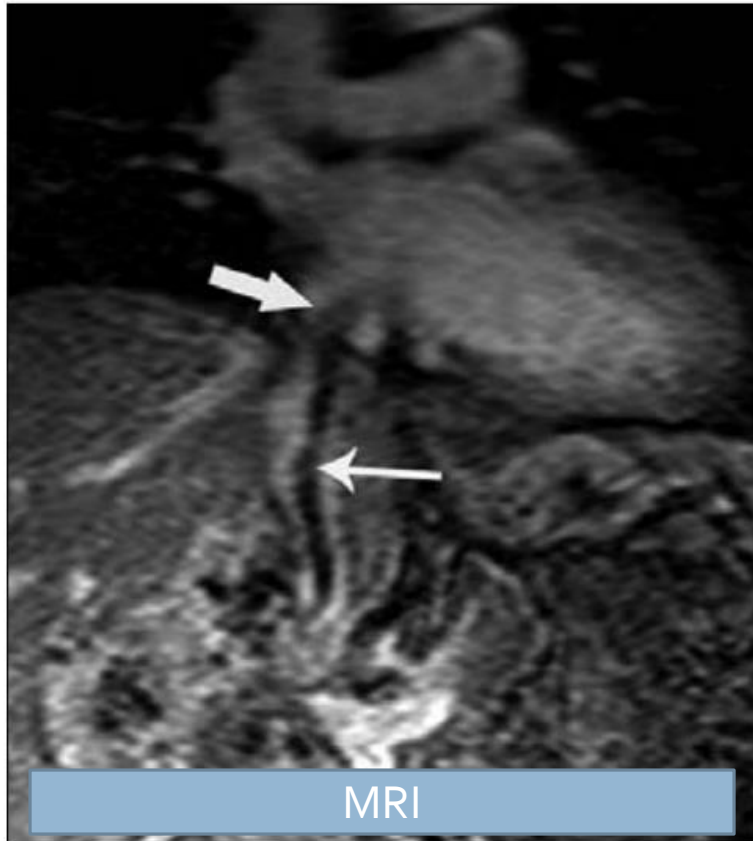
Magnetic resonance imaging of the abdomen showing a 9 cm × 8 cm right renal mass and a filling defect (tumour extension) in the inferior vena cava (thin arrow) with protrusion into the right atrium (thick arrow)
